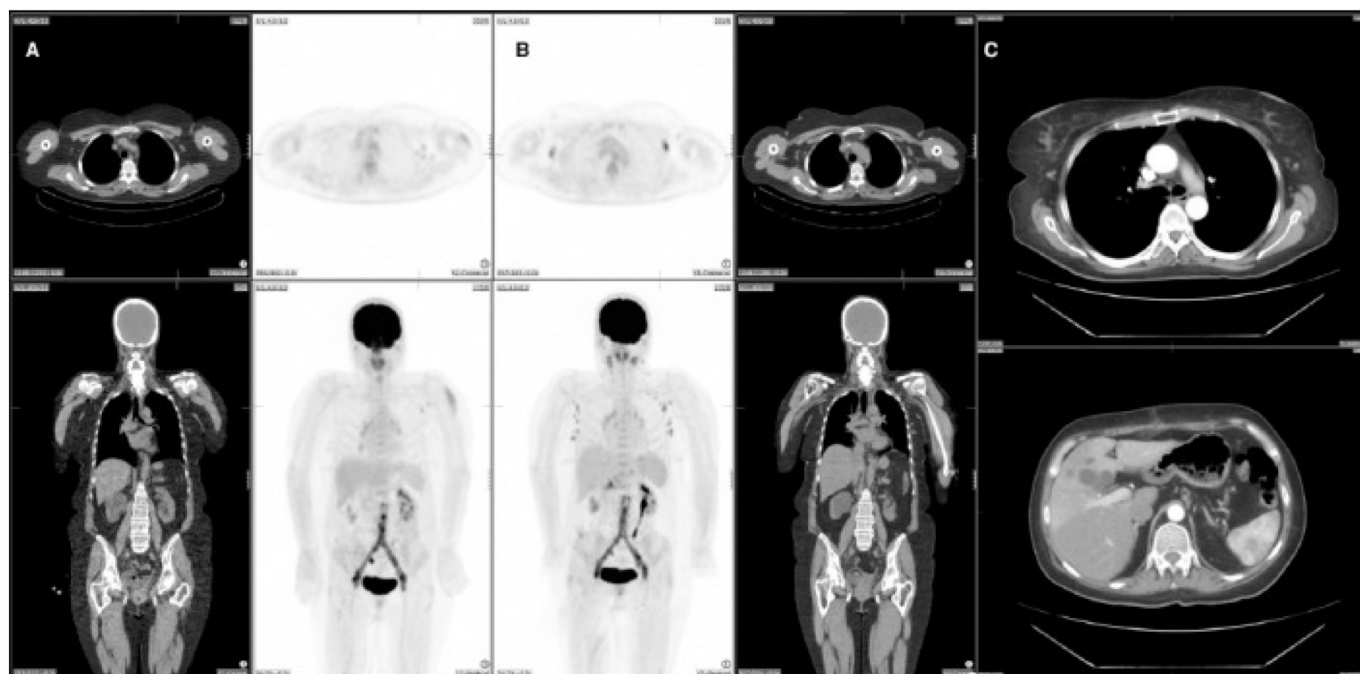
Generalized lymph node activation in FDG PET-CT, following influenza vaccination, in a patient who was referred for investigation of an infected graft. The first FDG PET/CT study (A) reveals increased activity in the left deltoid and ipsilateral axillary lymph nodes. The second study (B) demonstrates multiple FDG-avid lymph nodes on both sides of the diaphragm, including bilateral cervical, bilateral axillary, coeliac, porta hepatis, and left femoral regions (B). The patient underwent CT angiogram (C) three months after removal of the infected graft, which shows no lymphadenopathy above or below diaphragm. Images are obtained from Ayati N et al.⁴¹
